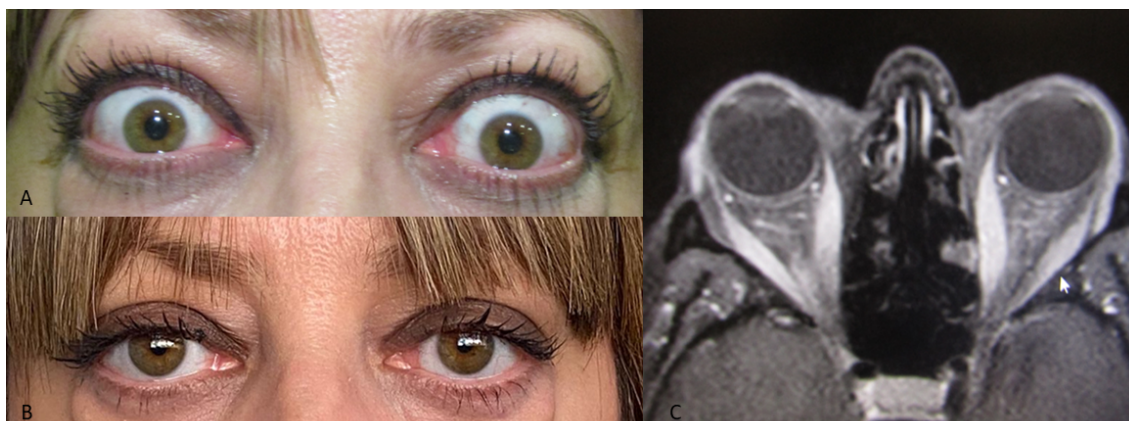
A, Baseline characteristics of a patient diagnosed with Graves Orbitopathy, with exophthalmia, eyelid edema and eyelid retraction, corresponding to a Clinical Activity Score of 3; B, the same patient after 4 sessions of sarilumab, with improved exophthalmia, eyelid edema and retraction; C, Baseline Magnetic Resonance Imaging of the same patient showing extra-ocular muscles enlargement.
